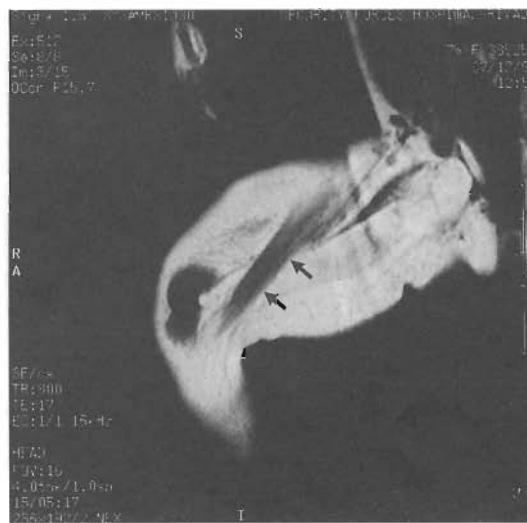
MRI scan (800/17 SE) of the left thigh (Case 1) revealed the sartorius muscle (arrows) to be the only remaining muscle. Other muscles were replaced by adipofibrous tissue.
